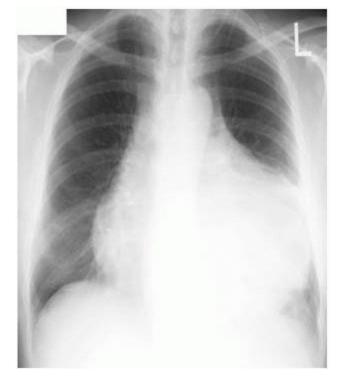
Radiograph showing a large pericardial effusion. The heart appears grossly enlarged with a typical 'boot' shape.
